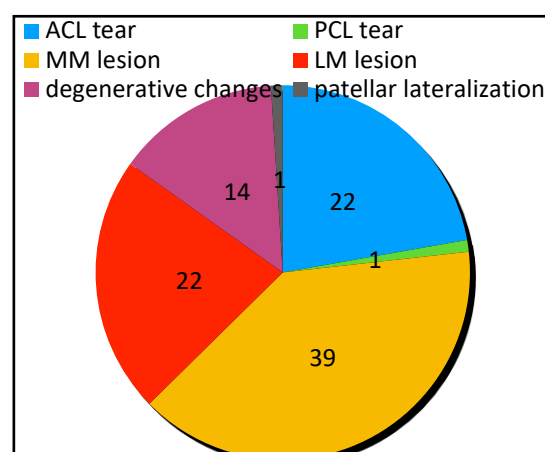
a: Distribution number of knee pathology by MRI.
